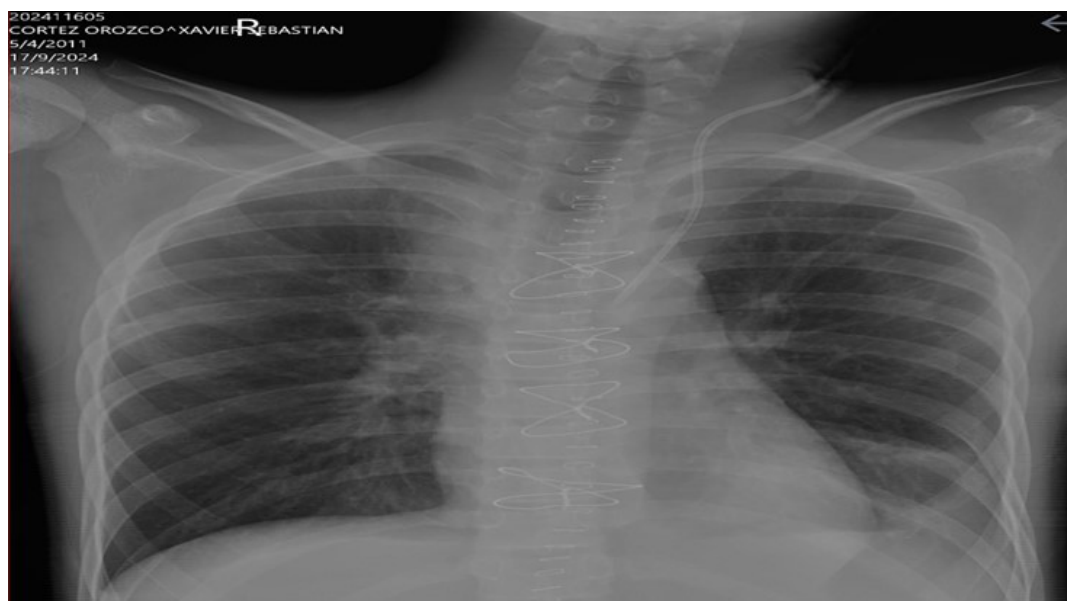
Radiographic control of postoperative evolution of anterior mediastinal tumor exeresis
